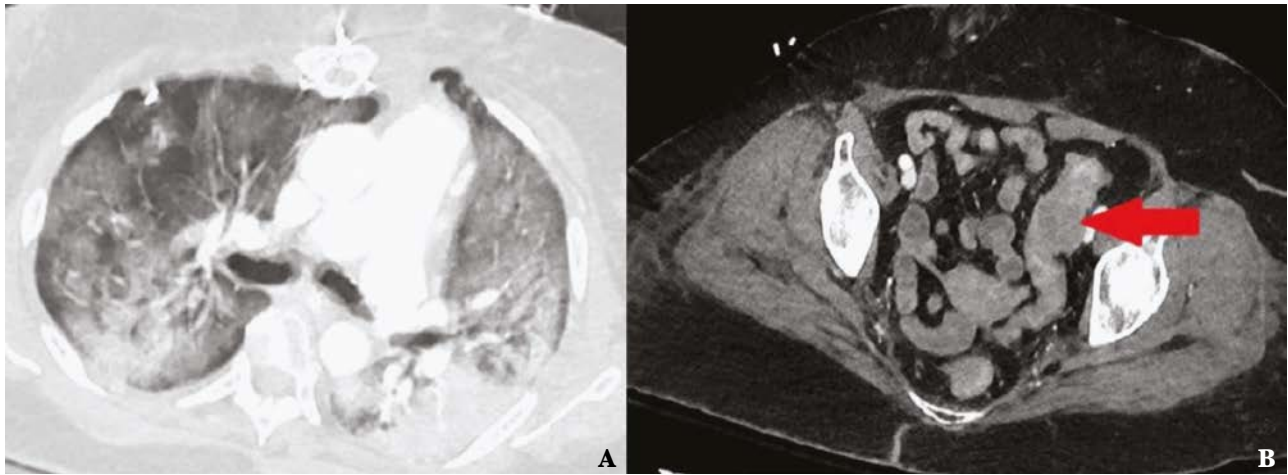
A, Computed tomographic (CT) scan of the thorax demonstrating diffuse pulmonary infiltrates with ground-glass predominance and associated consolidations. B, CT scan of the abdomen with arrow indicating region of significant thickening along the sigmoid colon.
